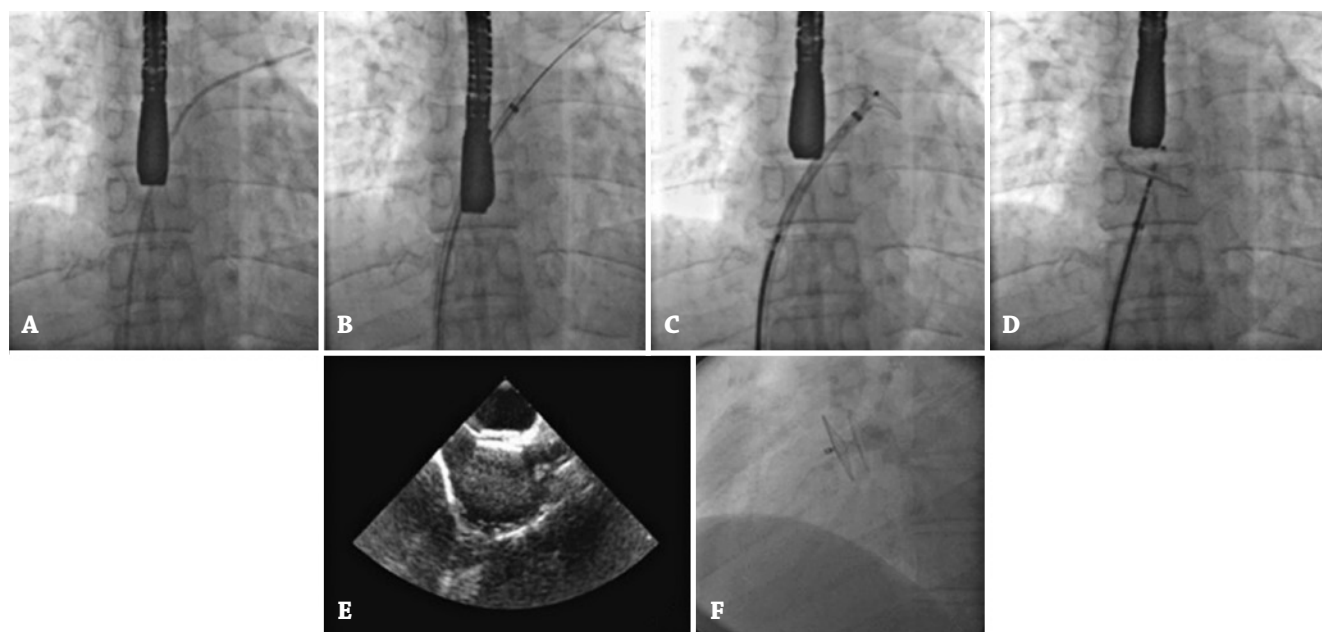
Left-to-right patent foramen ovale occlusion procedure stages: catheter in the pulmonary vein (A), sheath in the left atrium (B), left (C) and right (D) disk deployment, echocardiographic (E) and fluoroscopic (F) view of the prosthesis.
